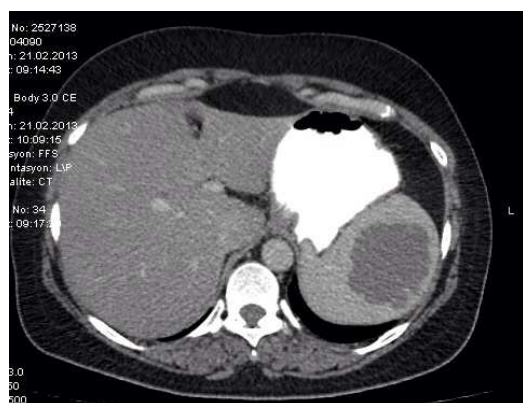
CT scan of the abdomen. Splenic multiloculated cystic lesion.
